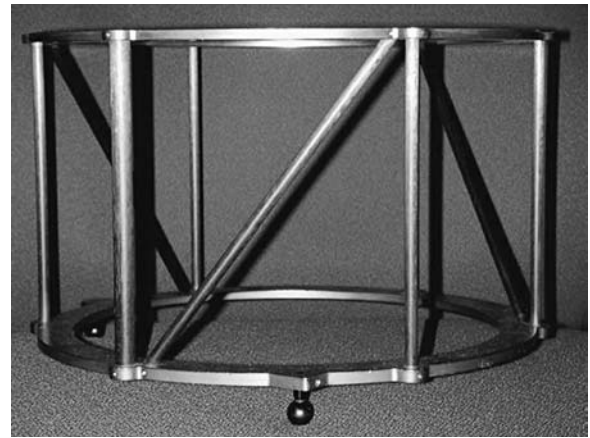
The CRW CT scan localizer (Radionics, Burlington, MA): The fiduciary system is composed of vertical outer bars and a diagonal internal one. Fiducial markers allow a precise 3D targeting.
